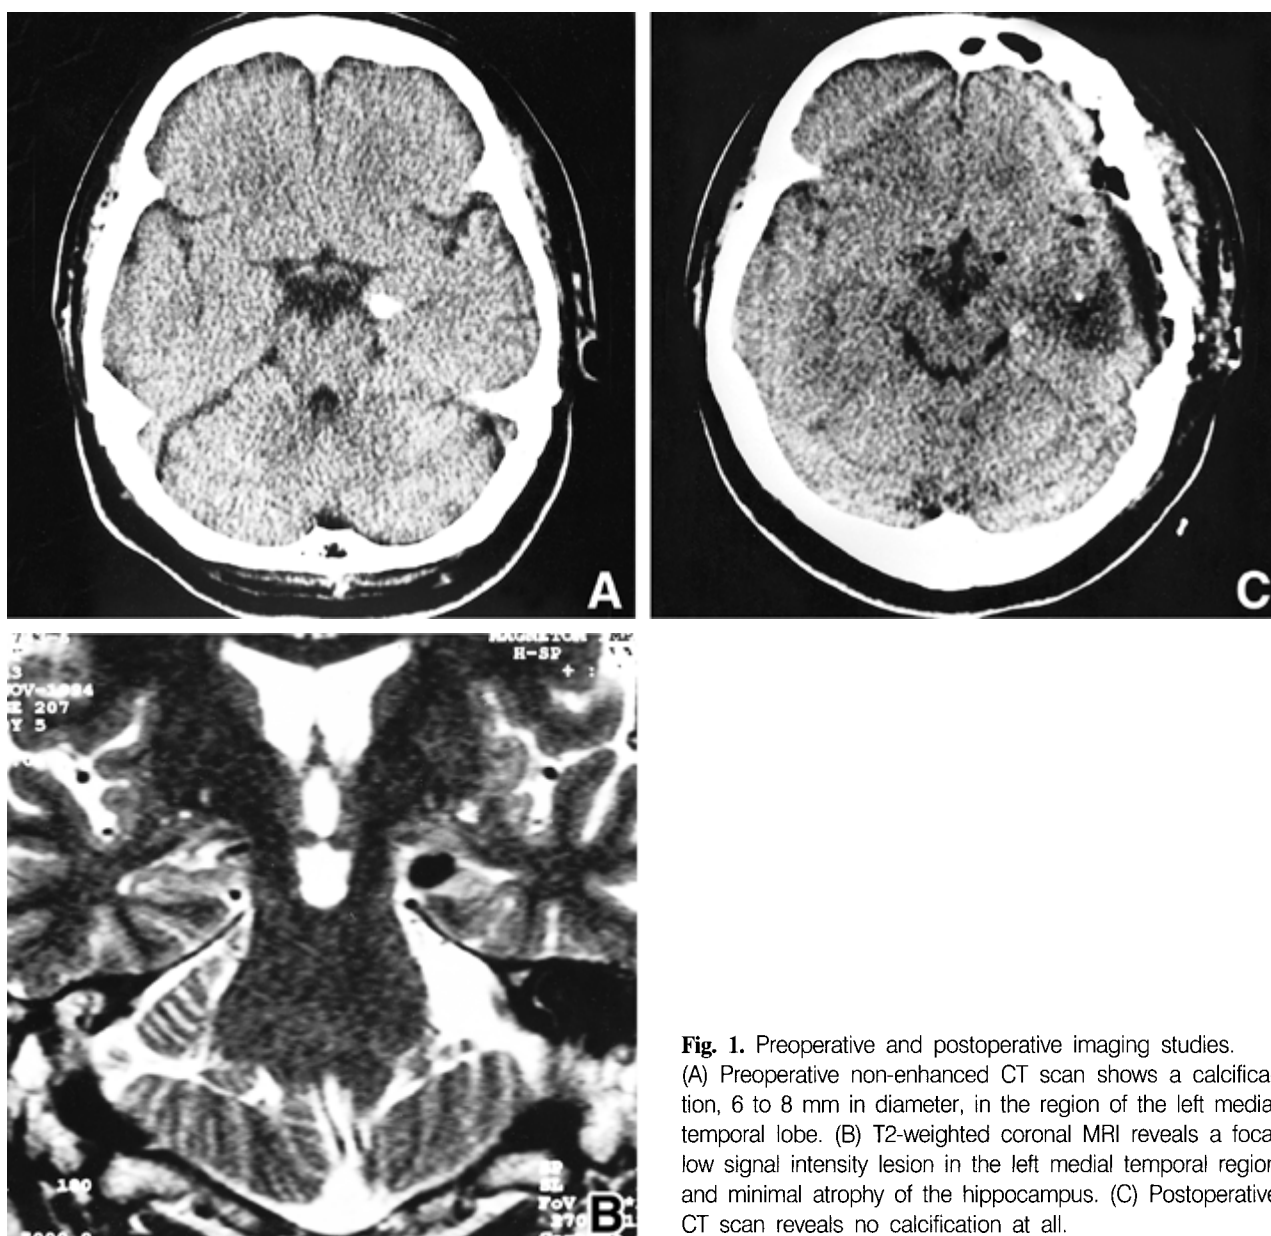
Preoperative and postoperative imaging studies. (A) Preoperative non-enhanced CT scan shows a calcification, 6 to 8 mm in diameter, in the region of the left medial temporal lobe. (B) T2-weighted coronal MRI reveals a focal low signal intensity lesion in the left medial temporal region and minimal atrophy of the hippocampus. (C) Postoperative CT scan reveals no calcification at all.
